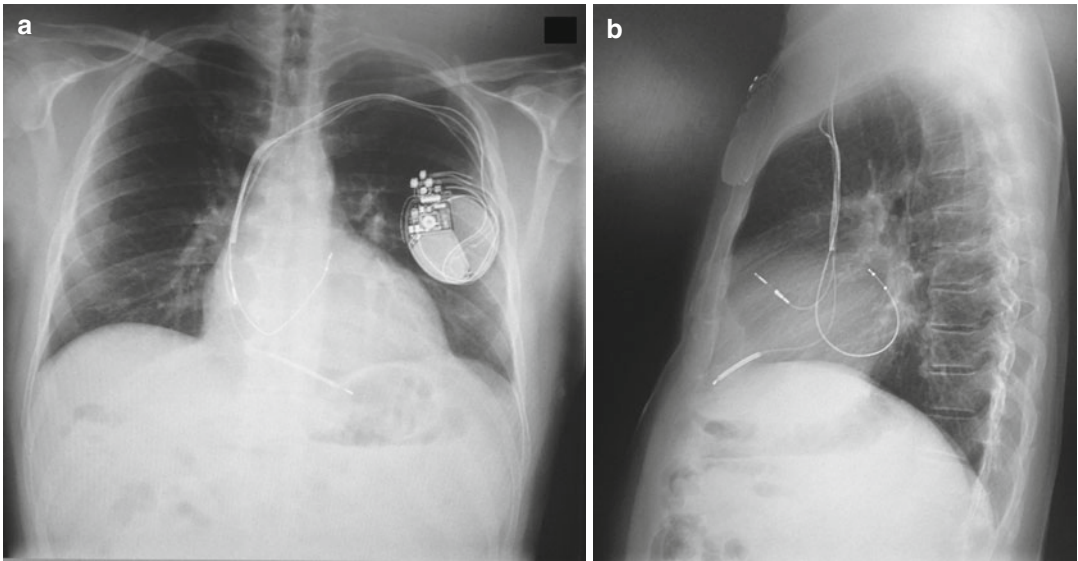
(a) Posteroanterior chest X-ray showing the left ventricular lead displacement. (b) Latero-lateral chest X-ray confirming the left ventricular lead displacement
